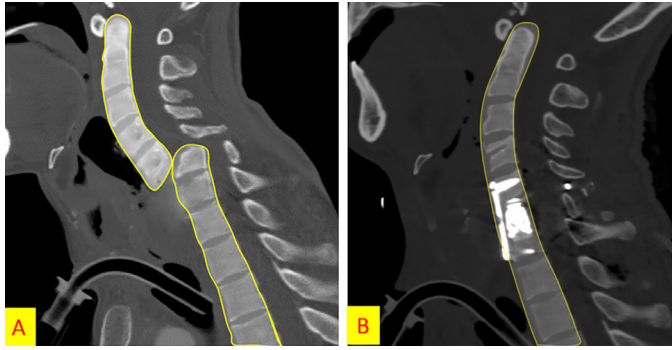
The preoperative (A) and postoperative (B) sagittal CT scan images show preoperative fracture and dislocation at C5-C6 level and postoperative instrumentation
